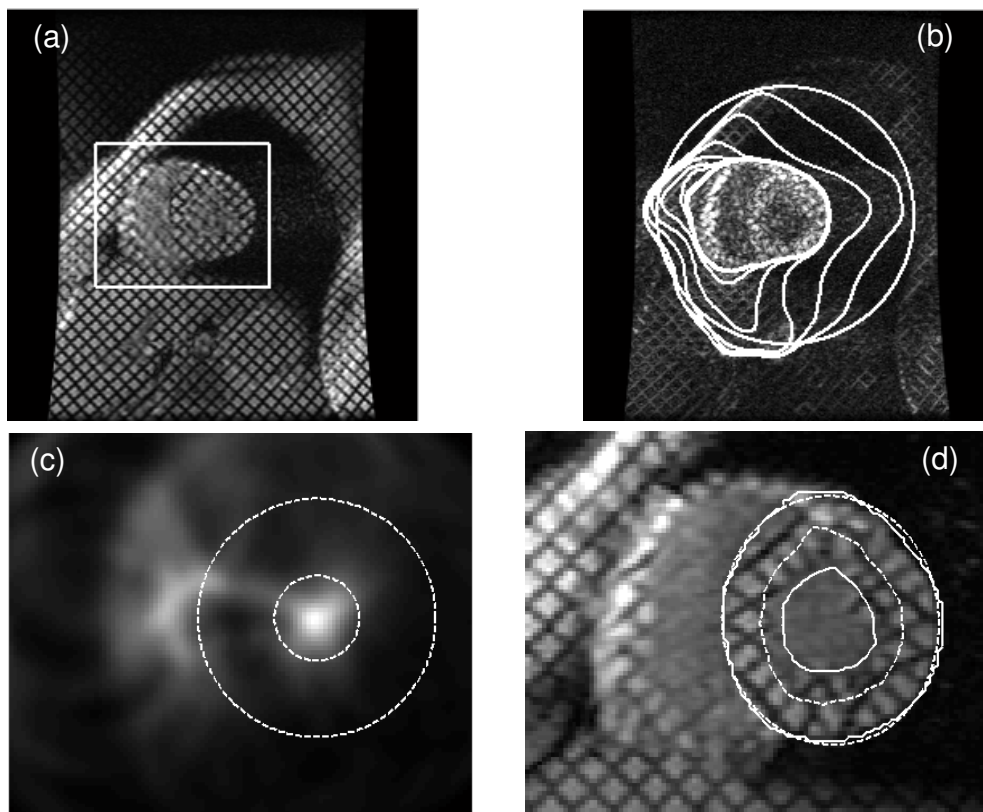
(a) Tagged cardiac MR image acquired using the SPAMM protocol with the grid of dark lines clearly visible. The rectangular area shown in the image represents part of the MR images which is automatically located from Step 2 and used for the myocardial boundaries estimation.
